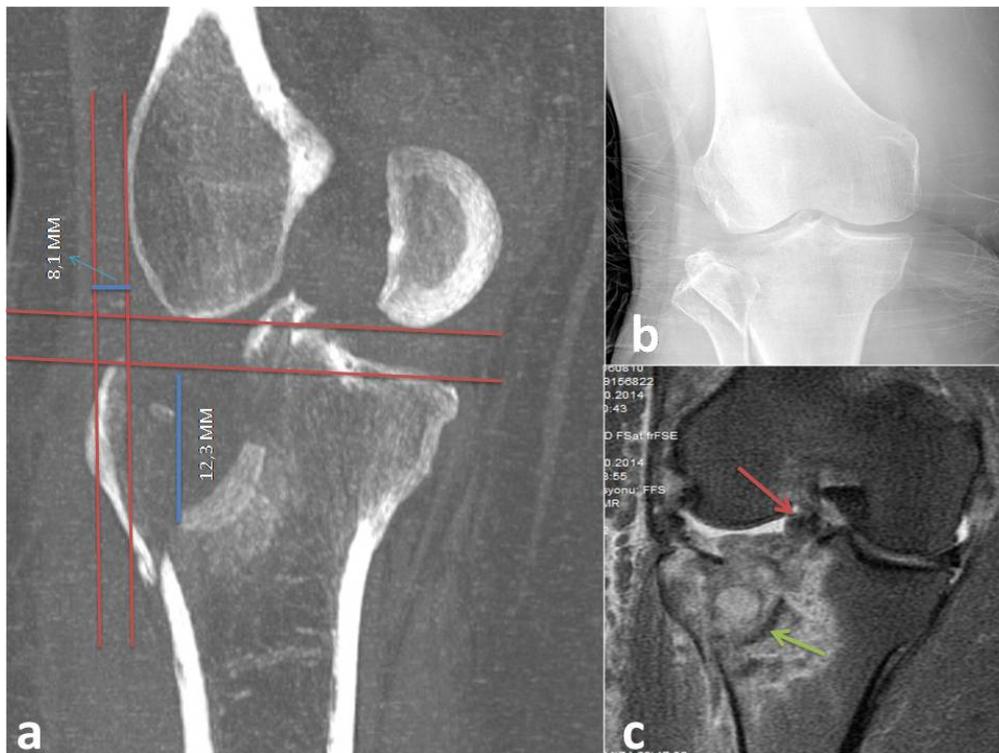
a) Measurement of joint depression and lateral widening in tibial plateau fracture on CT. The distance between the tibial joint line drawn parallel to the femoral condylar line and the most distally collapsed joint part indicates joint depression. The distance between the lateral femoral condyle and the lateral tibial plateau indicates joint widening. b) X ray. c) Red arrow indicates lateral meniscus bucket handle tear. Green arrow indicates displaced articular surface on MRI.
